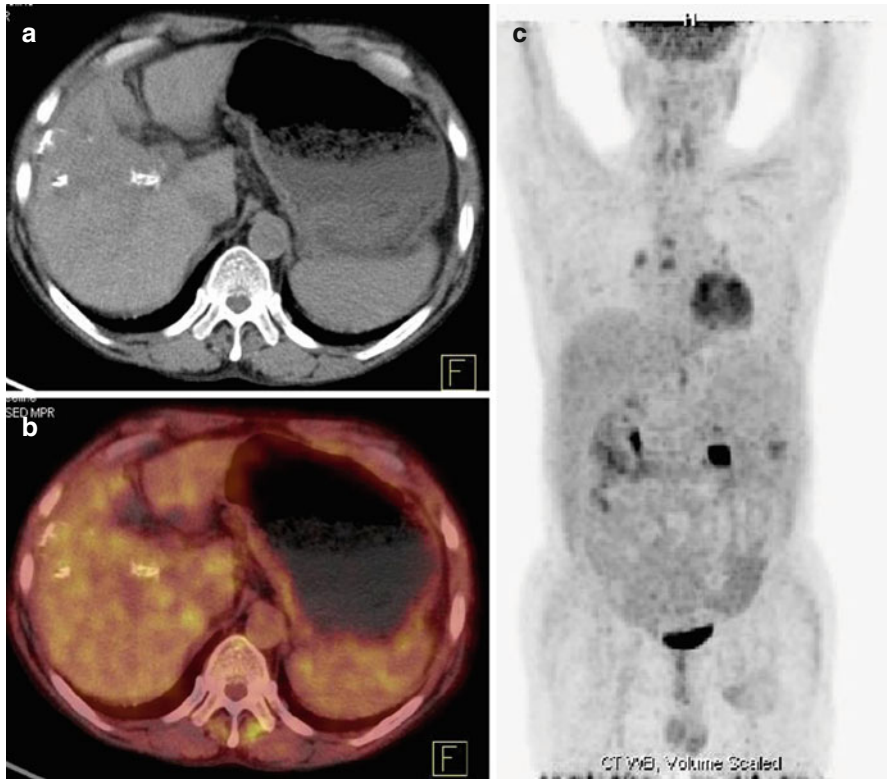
A 55-year-old man, after transarterial chemoembolization of a hepatocellular carcinoma with alpha foetoprotein level of 14.6 ng/ml. CT (a) showed an ill-defined hypodense lesion with multiple calcific areas and PET-CT (b) showed mild FDG uptake in the region suggestive of minimal residual disease. MIP (c) did not reveal any distant metastases
